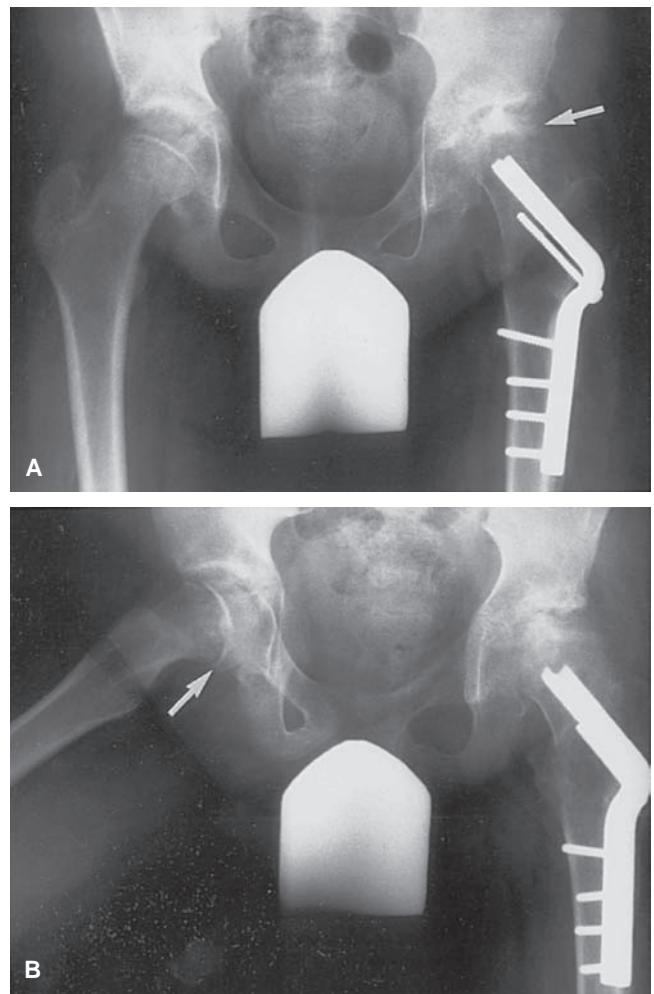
Radiographs of the hips of a teenager with bilateral slipped capital femoral epiphysis. A: Despite surgical intervention, significant avascular necrosis of the femoral head has occurred (*arrow*). The right hip appears normal. B: On a simultaneous frog-leg view, however, it can be seen that the right capital femoral epiphysis has also slipped (*arrow*).
